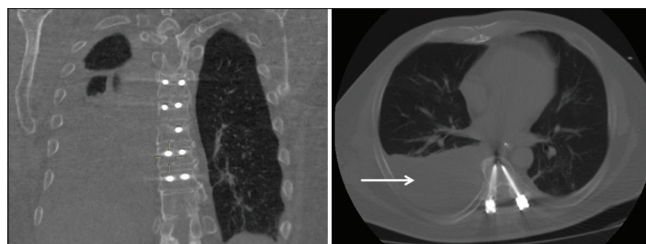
CT images of the thorax showing right sided pleural effusion (arrow)
